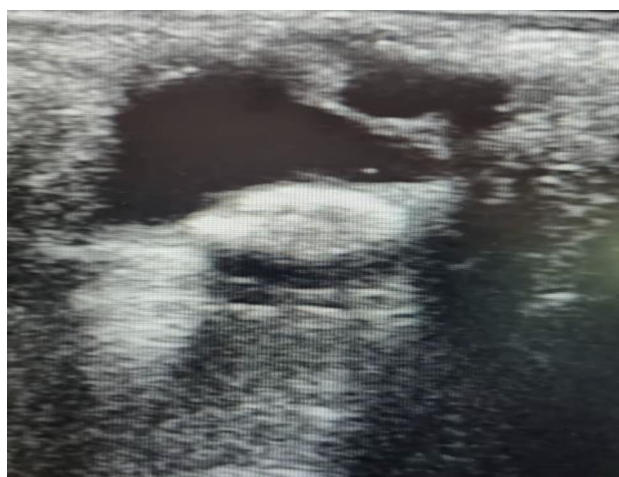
Left ocular sonogram in the transverse plane showing posteriorly dislocated left lens, vitreous degeneration and hemorrhage. Shaggy appearance of the outline of the left globe is also noted.
